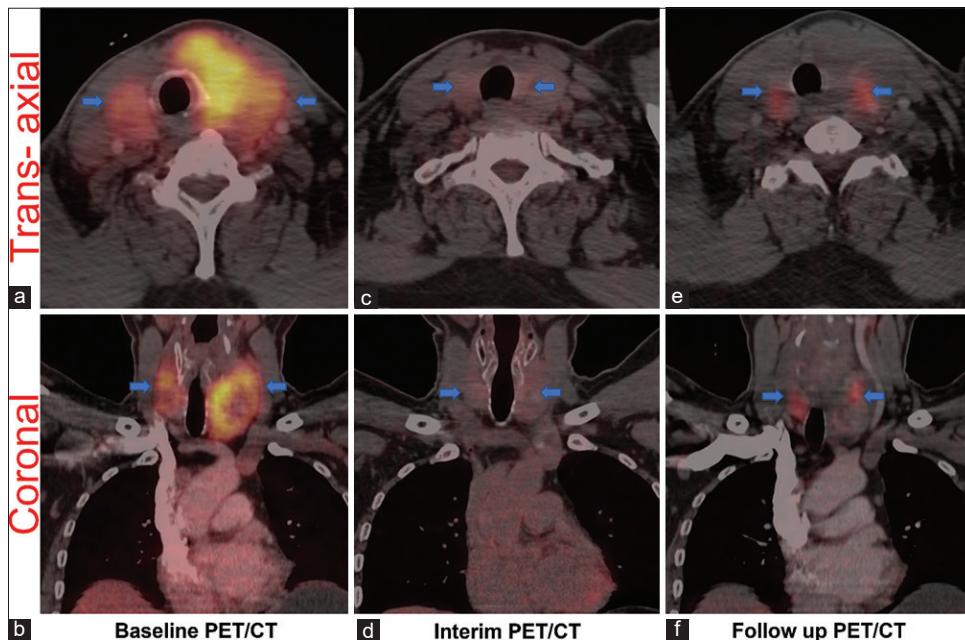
Baseline images (a and b) revealed increased uptake in the large mass in the thyroid region (blue arrow). Interim images (c and d) revealed complete disappearance of FDG uptake and resolution of mass suggestive of excellent response. End cycle PET/CT revealed a complete response (not shown). Patient noticed recurrent thyroid swelling 1 year later, follow up Images revealed increased uptake in bilateral thyroid bed suggestive of recurrence (e and f, blue arrow) which turned out to be false positive on Biopsy
